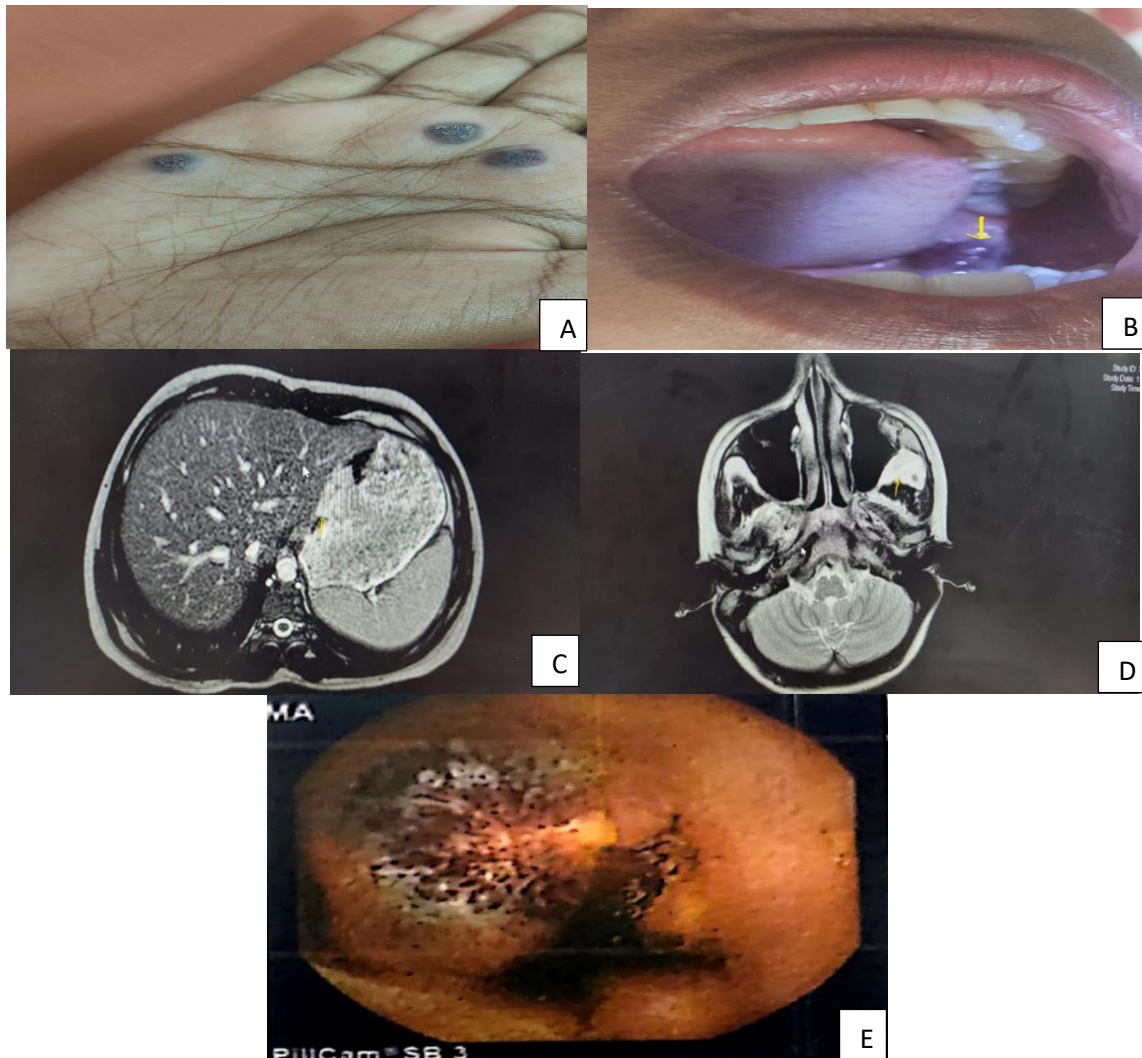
A) Bluish, rubbery, non-tender, compressible lesions on the palmar surface of hands. B) Mucocutaneous lesions in oral cavity. (C&D) T2/SPAIR images of brain and abdomen showing multiple hyperintense ill-defined areas, blooms on GRE, bright on DWI ND ADC with persistent delayed enhancement suggestive of slow flow vascular malformations-consistent with blue rubber bleb syndrome. E) Capsule endoscopy showing vascular malformation in the esophagus.
